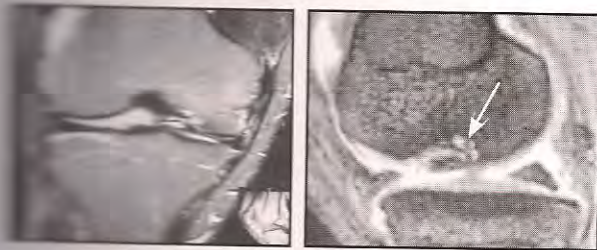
MRI optimizes resolution of the articular chondral surface.
